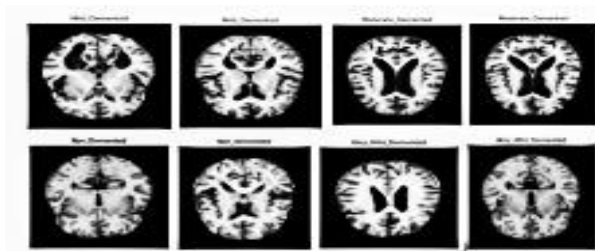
Enhancement of MRI images using color transformation
